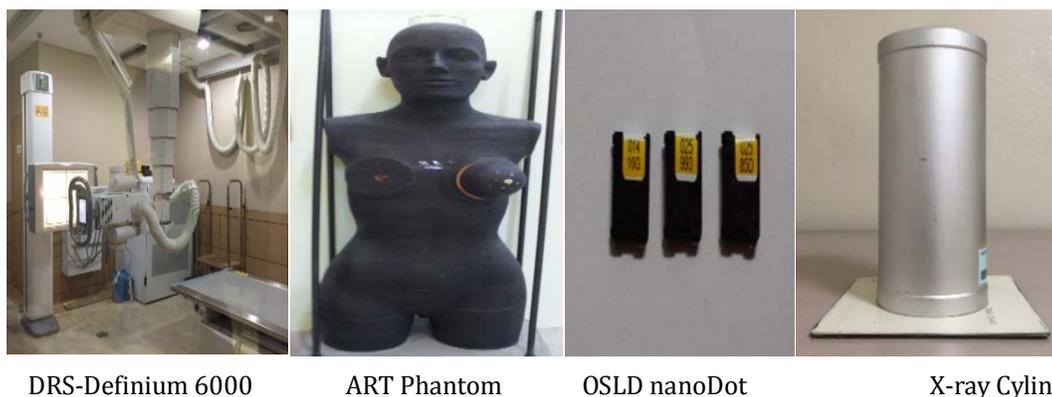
X-ray Equipment
